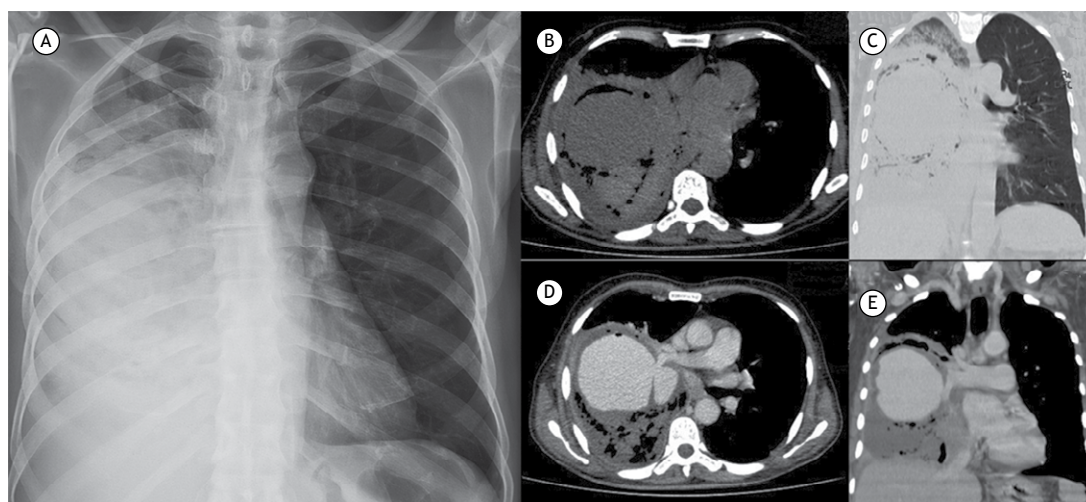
Anteroposterior chest X-ray (in A) showing opacification of the lower two thirds of the right lung. Unenhanced axial CT scan (in B) and coronal reconstruction (in C) showing extensive parenchymal consolidation, with air surrounding a nodule within the consolidation (the air crescent sign). Intravenous contrast-enhanced axial CT scan (in D) and coronal reconstruction (in E) showing intense enhancement of the intracavitary mass, leading to a diagnosis of aneurysm formation.
